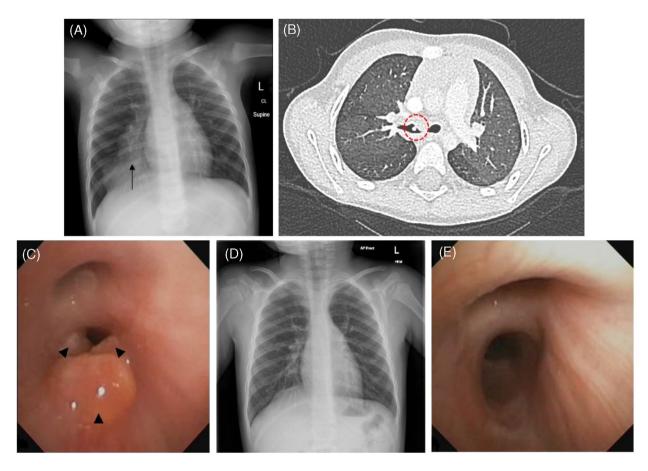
(A) Chest radiograph on presentation revealing increased opacification of the right middle and lower zones (black arrow). (B) CT chest demonstrating an endoluminal nodule within the right main bronchus (marked with red circle). (C) Three of the four discrete polypoidal lesions noted in the right main bronchus on flexible bronchoscopy (black arrowheads). (D) Chest radiograph at 2 years post initial review revealing resolution of right middle and lower zone opacities. (E) Resolution of the lesions on repeat flexible bronchoscopy at 2.5 years post presentation.
